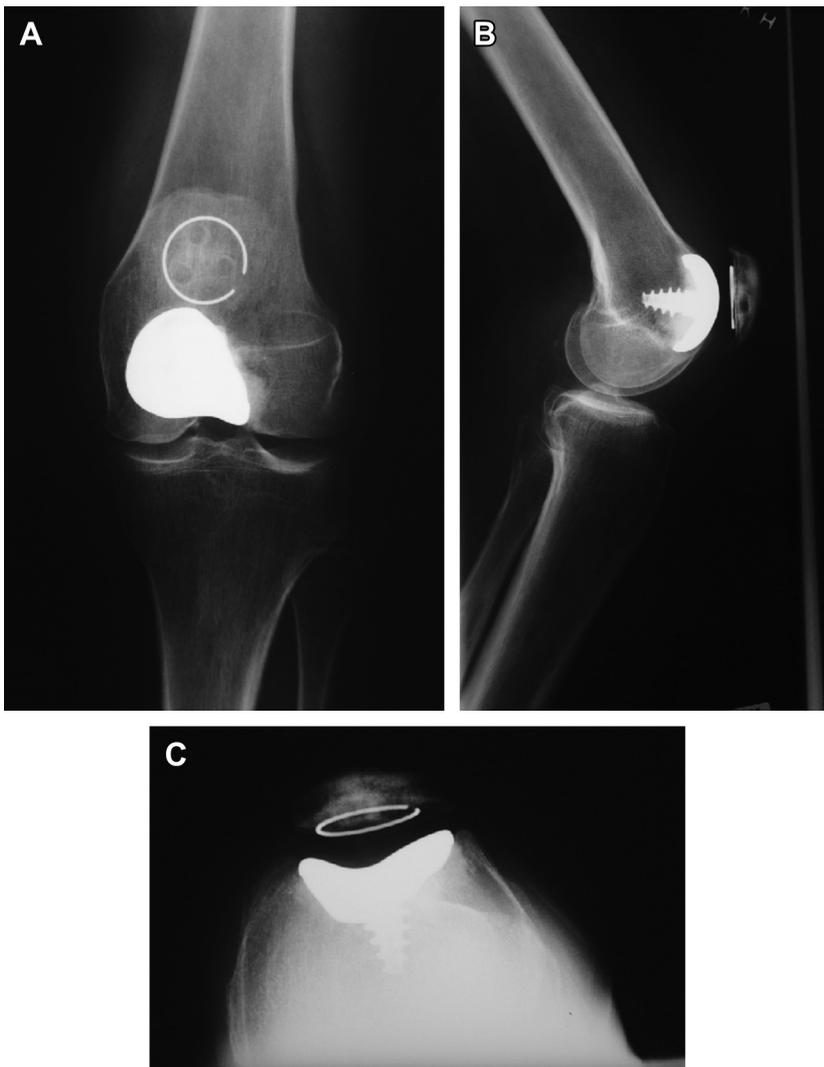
Inlay design patellofemoral arthroplasty prosthesis. Weight-bearing anteroposterior (A), lateral (B), and sunrise (C) radiographs.
